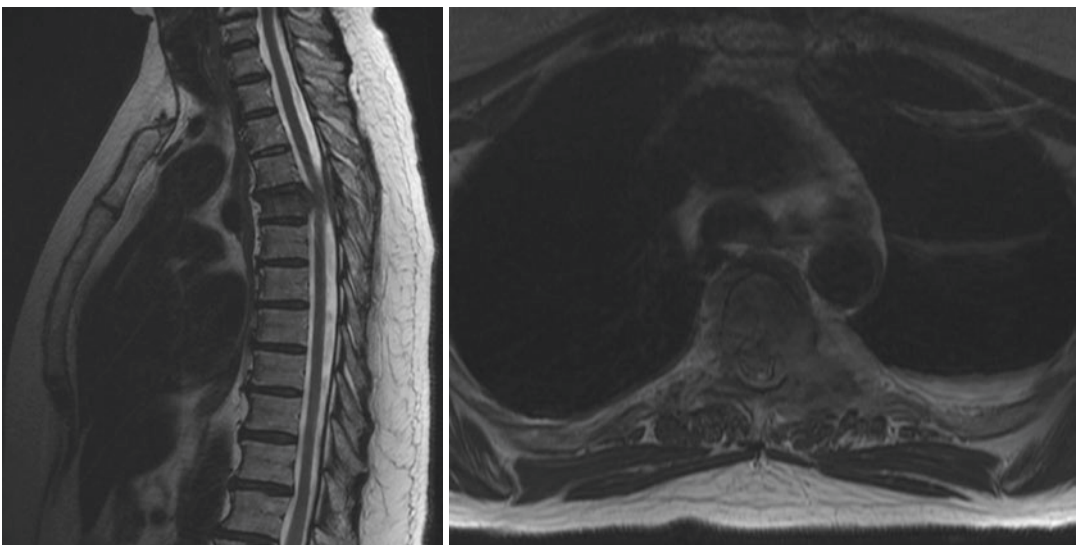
MRI demonstrating T5 pathologic fracture with epidural extension and associated mild cord compression
